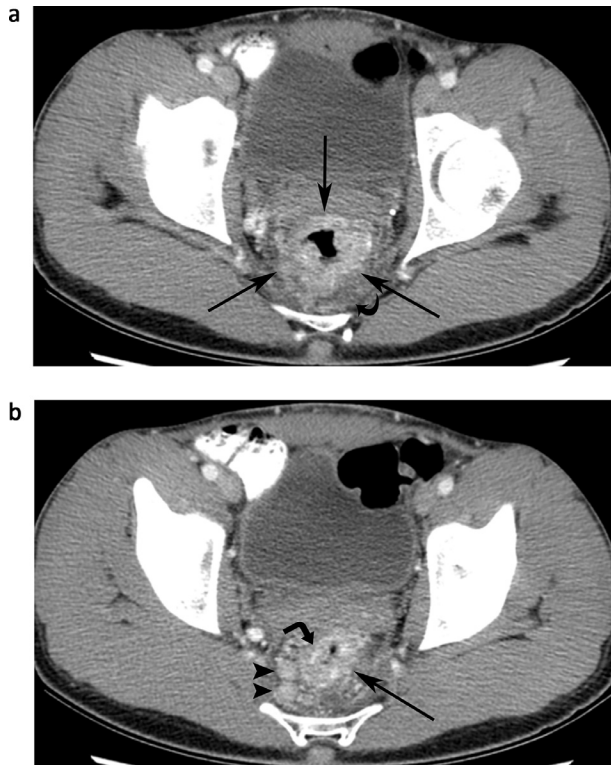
(A) Axial image from contrast-enhanced CT of the abdomen and pelvis at the level of the femoral heads demonstrating circumferential wall thickening of the rectum (black arrows) and perirectal fat stranding and induration (curved arrow). (B) Axial image of contrast-enhanced CT at the level of the low rectum demonstrating rectal wall thickening (black arrows), submucosal edema (right angle arrow) and right-sided perirectal lymphadenopathy (black arrow heads).
